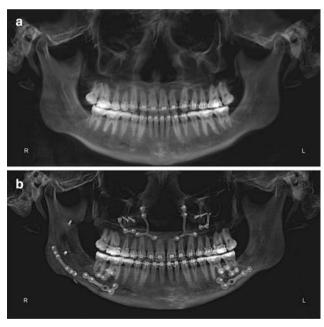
Panoramic view of presurgery and 1-year post-double jaw surgery. The second image shows repair of the buccal segment and subcondylar bony fractures that were managed during surgery. (a) Presurgery panoramic radiograph. (b) Post-surgery panoramic radiograph
